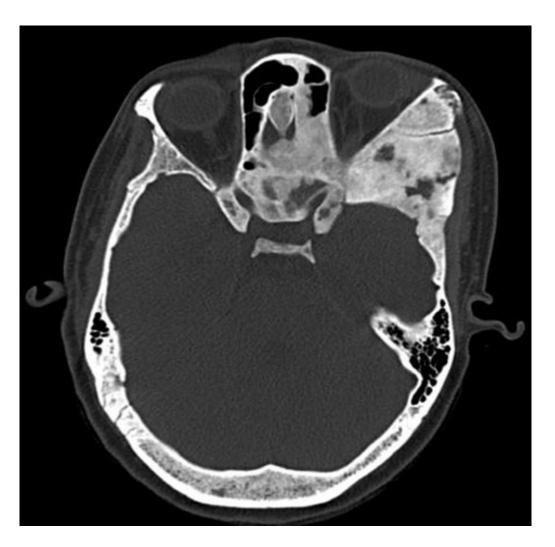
Fibrous dysplasia. HRCT axial image shows expansile ground glass opacification involving squamous part of left temporal bone (arrow). Similar involvement of the frontal bone, greater and lesser wing of sphenoid, walls of maxillary sinus, zygoma, roof of orbit and nasal turbinates on the left side was seen. These findings were suggestive of fibrous dysplasia.
